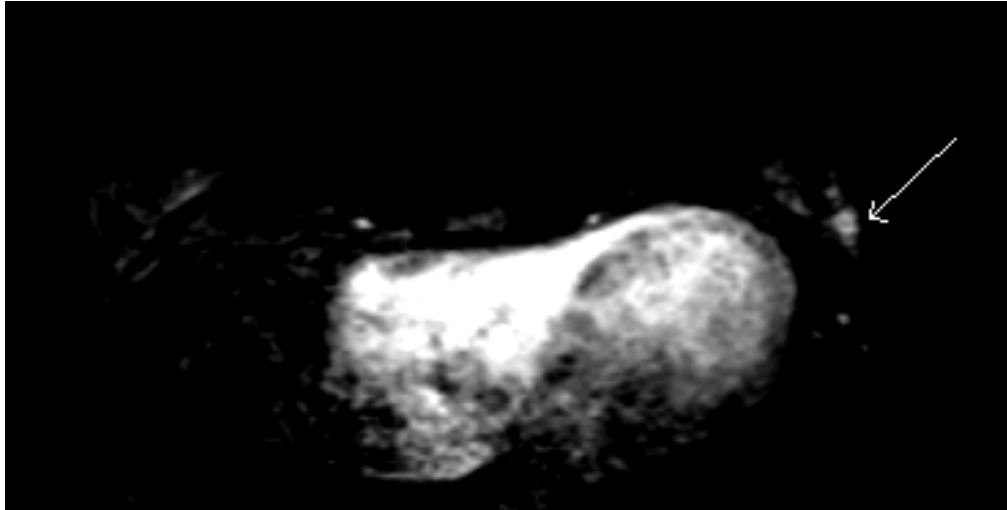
Axial MRI subtracted with TWIST®: lesion of left breast is visible with higher signal intensity than BPE (white arrow)
